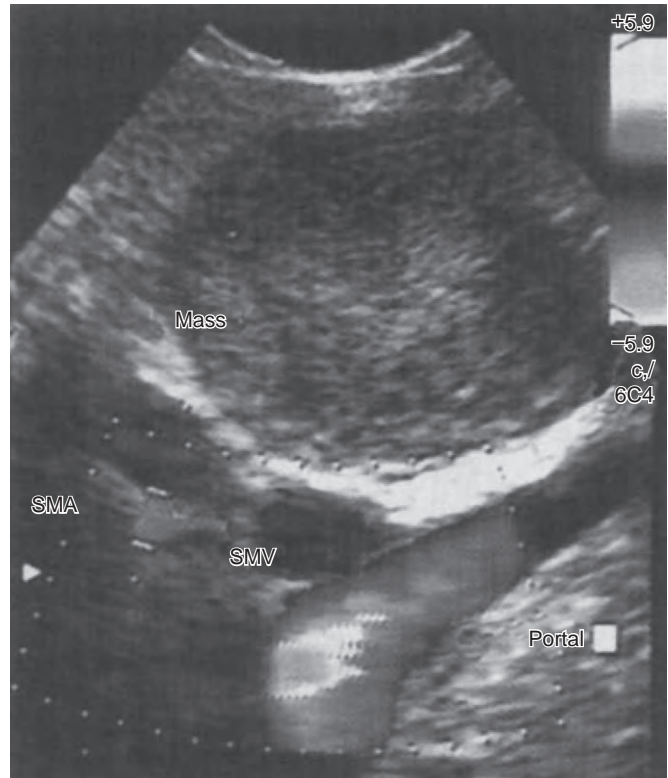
Endoscopic ultrasound image, with a linear-array echoendoscope, demonstrating a mass in the head of the pancreas with no vascular invasion of the superior mesenteric artery (SMA), superior mesenteric vein (SMV), or portal vein (Portal). (From Yeo CJ, Cameron JL: Pancreatic cancer. *Curr Probl Surg* 36:59-152, 1999.)
